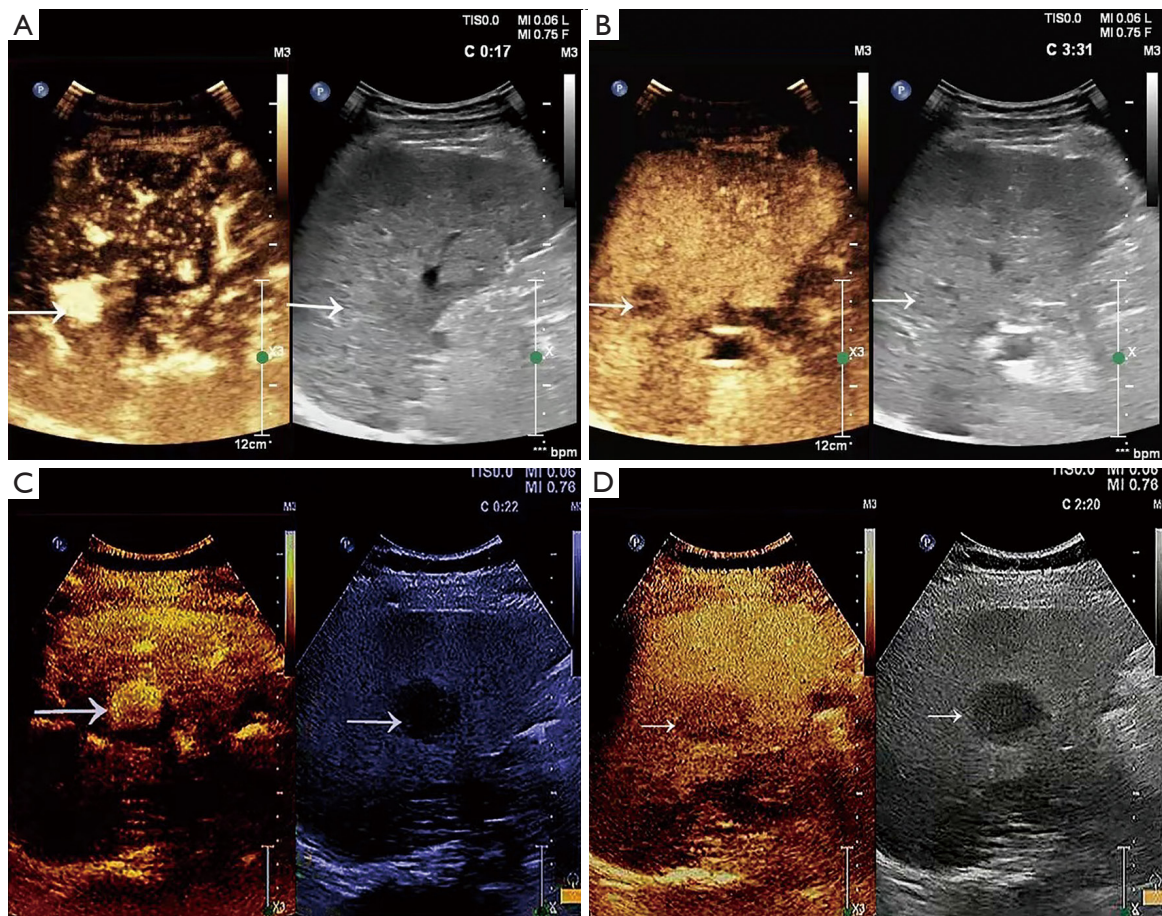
Representative imaging of two cirrhotic patients with early similar HCC using CEUS (left) and B-mode ultrasonography (right). Patient 1 with early HCC with a diameter of 16 mm × 15 mm (A: arterial phase, B: portal and delayed phases) and Patient 2 with early HCC with a diameter of 18 mm × 16 mm (C: arterial phase, D: portal and delayed phases). Early HCC in both patients showing hyperenhancement in the arterial phase and hypoenhancement in the portal and delayed phase. The arrows refer to the location of HCC. HCC, hepatocellular carcinoma; CEUS, contrast-enhanced ultrasonography.
